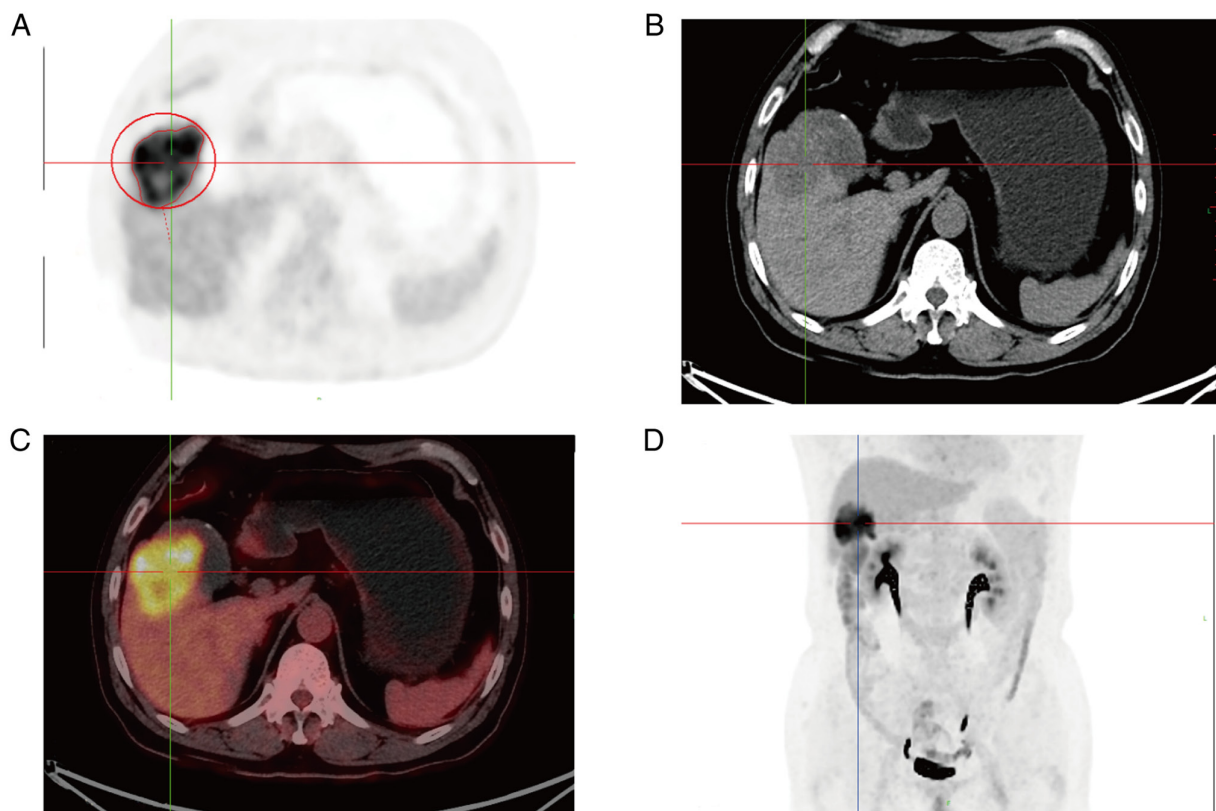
Chest and abdominal PET/CT images of case 1. (A) PET imaging 1 h after FDG injection. (B) CT imaging 1 h after FDG tracer injection. (C) 1 h after injection of FDG tracer, PET/CT fusion imaging. (D) Maximum intensity projection. PET/CT, peoperative positron emission tomography/computed tomography; FDG, fluorodeoxyglucose.
